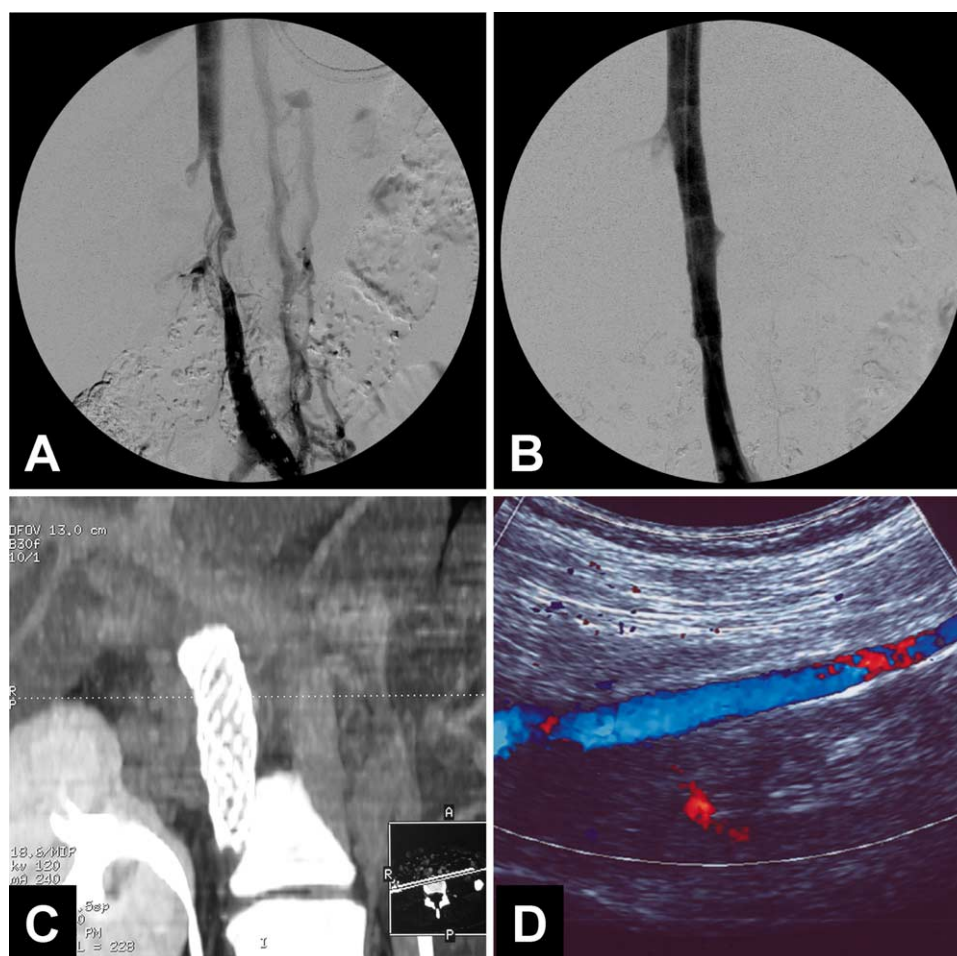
A 16-year-old female patient underwent transfemoral thrombectomy with subsequent ascending venography. The venous angiogram showed segmental hypoplasia of the inferior vena cava (A) with collateral venous drainage (TYPE III). The caval stenosis was treated by deployment of a Corinthian[®] stent resulting a patent IVC (B). One year after treatment the patient was completely free of discomfort, swelling, and pain. Follow-up CT imaging showed the stent location (C) and ultrasound confirmed a patent ilio-caval venous system (D).
